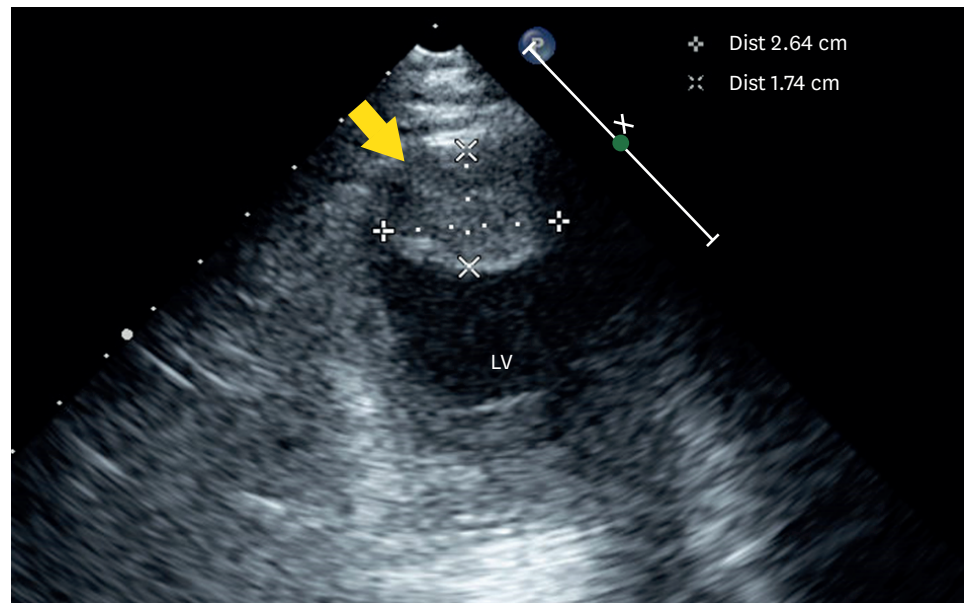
Echocardiography shows LV thrombus. The thrombus is 2.64×1.74 cm in the LV apical lesion. LV = left ventricular.
